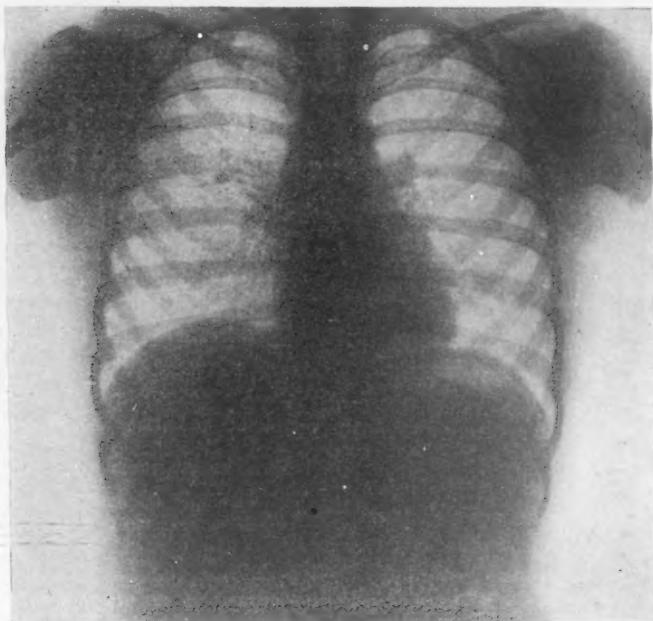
Lung abscess following tonsillectomy. Motor-driven anesthesia apparatus used. Abscess in right middle and lower lobes. This is the radiograph of my original case as reported (4). Note compensatory hypertrophy of left chest. This was the case which was criticised on the grounds that the abscess was due to the inhalation of a particle of tooth. The tooth was supposed to be near the diaphragm. It will be noted that the abscess itself is much higher up. The patient has been seen by Doctor Chevalier Jackson, in whose opinion there is no foreign body present.
